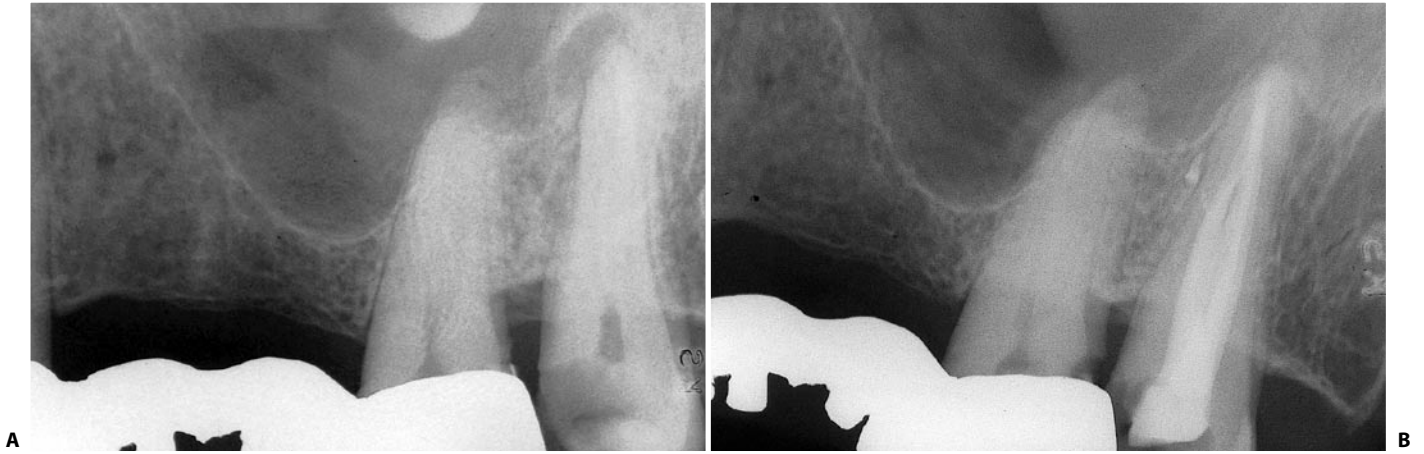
A. Preoperative radiograph of the maxillary third molar with a necrotic pulp. Two radiolucencies are evident: a larger one in the periapical area and a smaller one on the medial aspect of the middle one third of the root. B. Twenty-seven months later. Note that the two radiolucencies have healed. The smaller one was sustained by a lateral canal.
